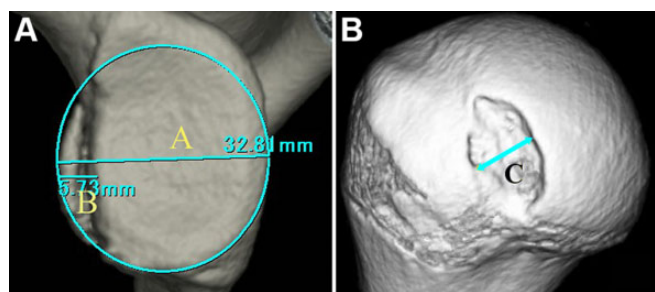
Quantification of glenoid defect size and Hill-Sachs lesion size on 3-dimensional (3D) computed tomography scan. (A) The extent of the glenoid defect: $B/A \times 100\%$, where A is the diameter of the fitted circle and B is the width of the glenoid defect. (B) Through use of en face 3D-reconstructed images that showed the Hill-Sachs lesion, the longest line connecting the medial and lateral edges of the lesion was defined as the lesion width, C . The humeral head diameter was defined as the diameter of the circle on the axial slice with the largest circle. Then, the size of the Hill-Sachs lesion was calculated as a percentage of the humeral head diameter.
